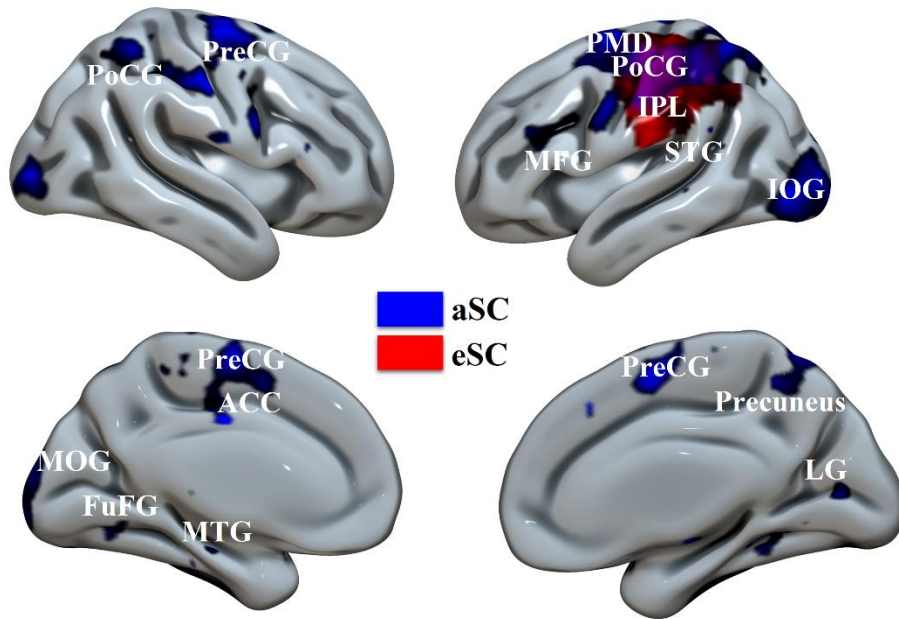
6. Whole-brain functional MRI analyses on aSC_{valid} > NEU and eSC_{valid} > NEU contrasts among older subjects. Activations blobs are corrected for multiple comparison using $P_{FWE} < .05$. Colour labels blue = allocentric spatial coding and red = egocentric spatial coding. MOG = middle occipital gyrus. LG = lingual gyrus. FuFG = fusiform gyrus. MTG = middle temporal gyrus. STG = superior temporal gyrus. IPL = inferior parietal lobule. PreCG = precentral gyrus. PoCG = postcentral gyrus. ACC = anterior cingulate cortex. PMD = premotor cortex. MFG = middle frontal gyrus.
